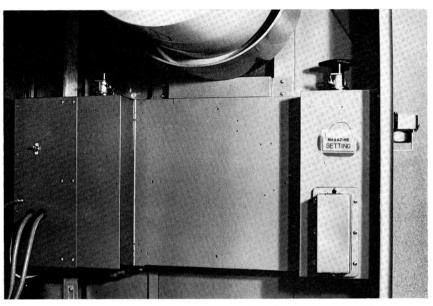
The full size roll film changer which is set out of x-ray beam range. A part of the image intensifier is visible above the changer.
